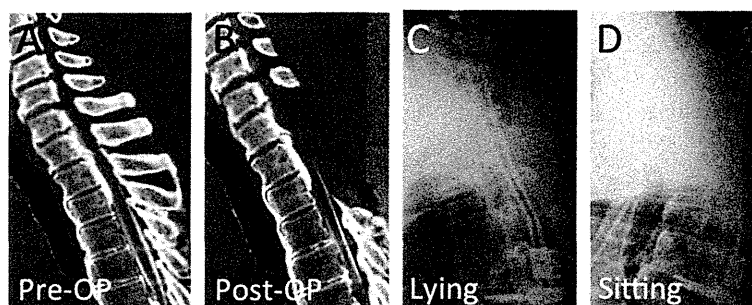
Pre- and postoperative images of Case 2. Pre-operative computed tomography image showed peak of ossification of the posterior longitudinal ligament at T1/2 vertebral level (A). C3-T5 posterior decompression with instrumented fusion surgery was performed. The patient showed incomplete paralysis on sitting, but rapidly recovered after bed rest. An emergent computed tomographic-myelogram revealed no apparent abnormalities (B). X-ray images obtained when the patient was lying (C) and sitting (D) showed no apparent motion between fused segments.
